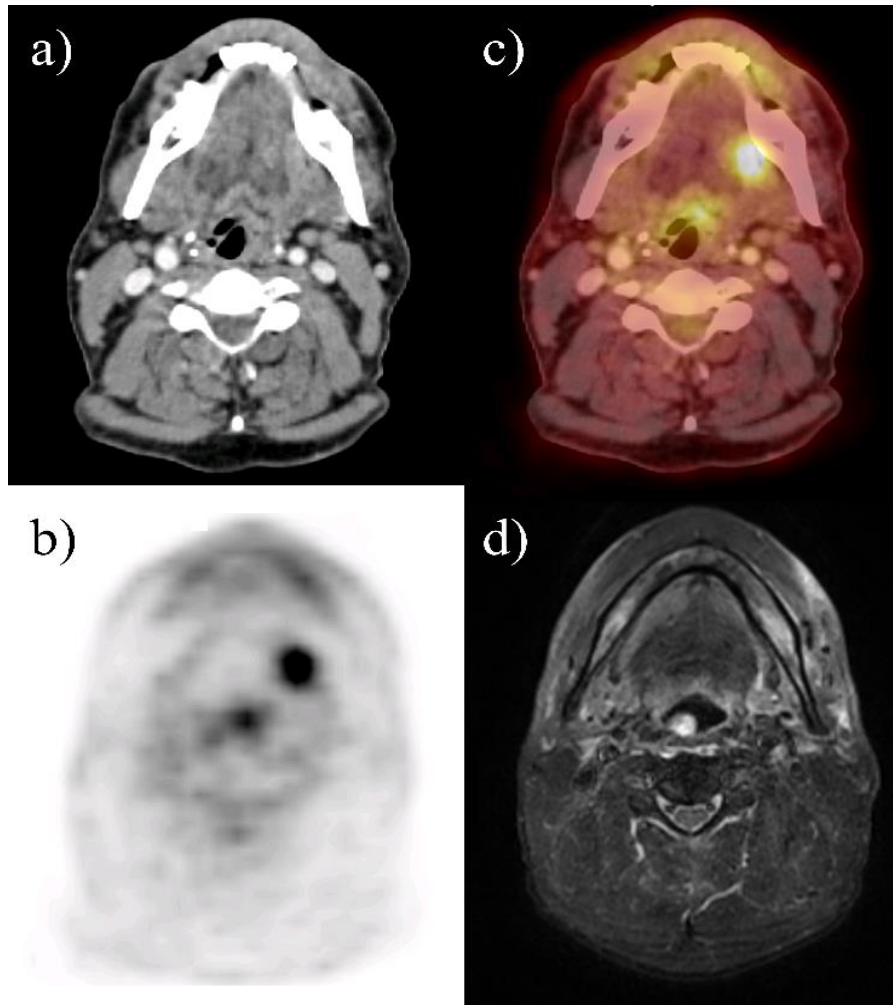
Different modalities in a head and neck patient. a) CT with contrast. b) PET. c) Registration of PET and CT, and d) MRI. As seen here, PET has the lowest resolution. MRI images are not suitable for RT calculations.
